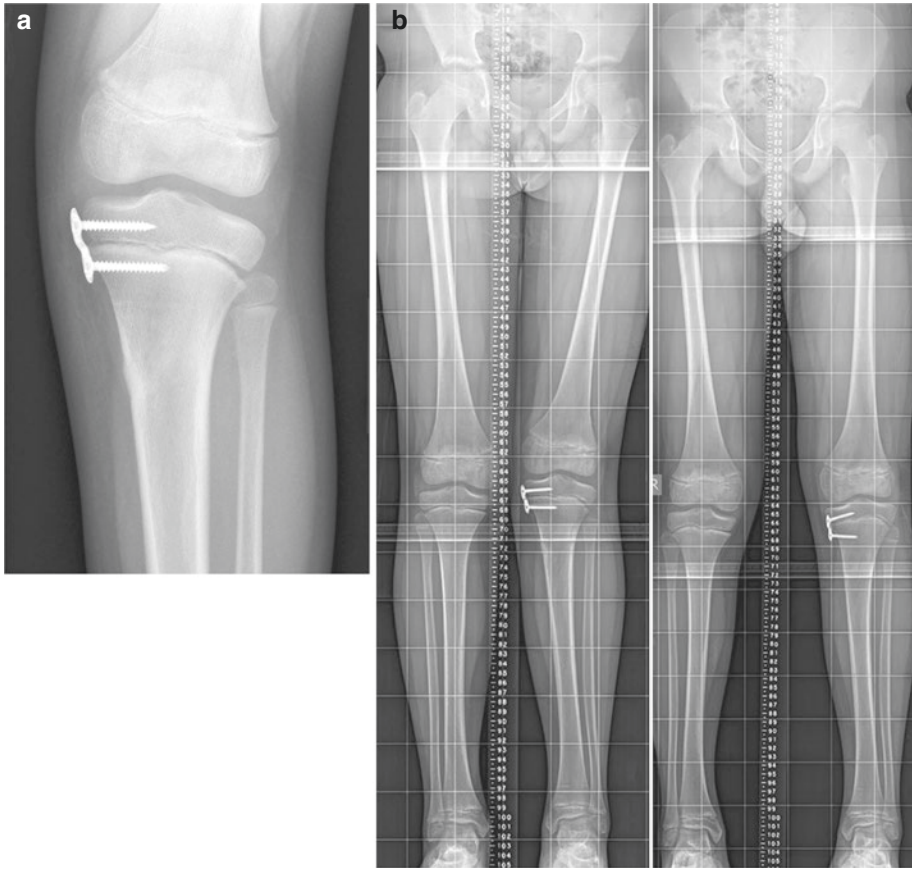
A 12-year-old male presented 10 months after a left proximal tibial metaphyseal fracture that developed progressive valgus angulation. (a) A growth tether was created by placing a small plate with two screws. (b) Standing radiographs immediately after this “guided
